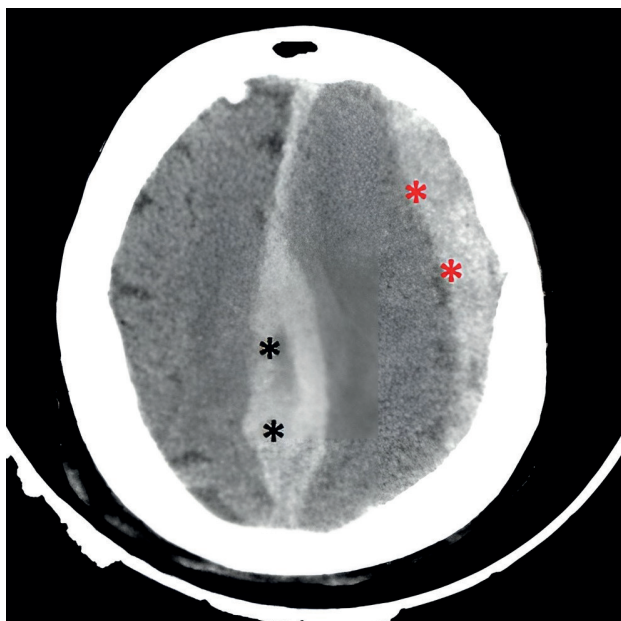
Preoperative computed tomography images of the patient. Acute subdural hematoma surrounding the cerebral convexity on the left, measuring 19 mm in its thickest part (red asterix). Parafalcine subdural hematoma, measuring 19 mm in its thickest part (black asterix).
